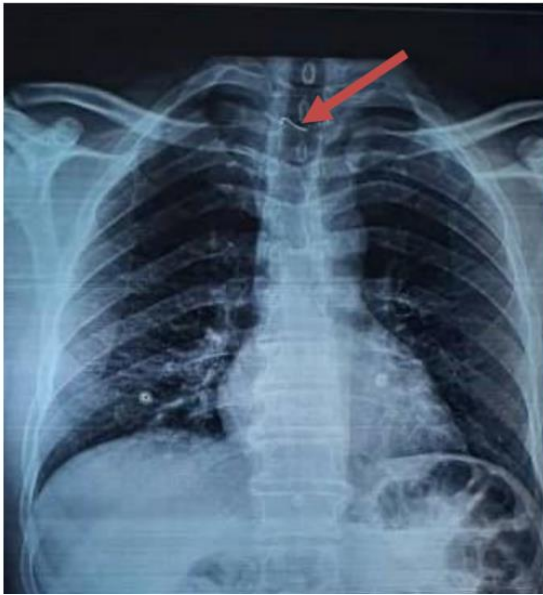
Frontal chest x-ray showing the presence of dentures with metal wire at the upper third of the esophagus.
